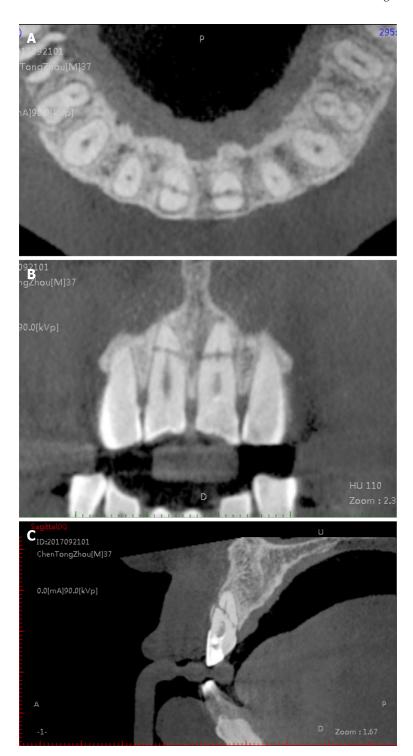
Pre-operative cone beam computed tomography imaging. A-C: Axial (A), coronal (B), and sagittal (C) views of the cone beam computed tomography showed that both of the maxillary central incisors had oblique fracture lines, and a 3 mm × 4 mm radiolucent lesion set around the fracture line.
